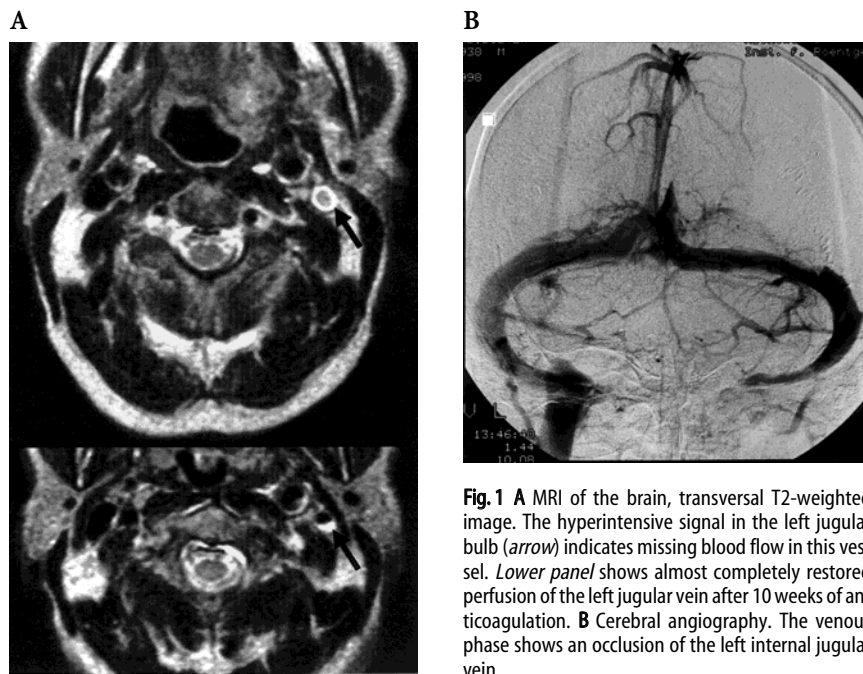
A MRI of the brain, transversal T2-weighted image. The hyperintensive signal in the left jugular bulb (*arrow*) indicates missing blood flow in this vessel. *Lower panel* shows almost completely restored perfusion of the left jugular vein after 10 weeks of anticoagulation. B Cerebral angiography. The venous phase shows an occlusion of the left internal jugular vein
